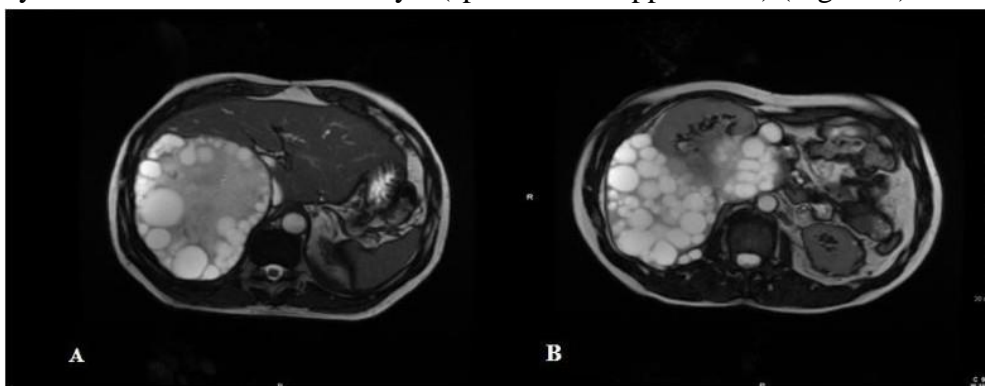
MRI T2 weighted images axial images showed typeIIA at hepatic right lobe H.cyst. Image A. showed spoke wheel appearance of the cyst and while image B. showed extra-hepatic H.cyst outpouching(Ettorre, 2012).
